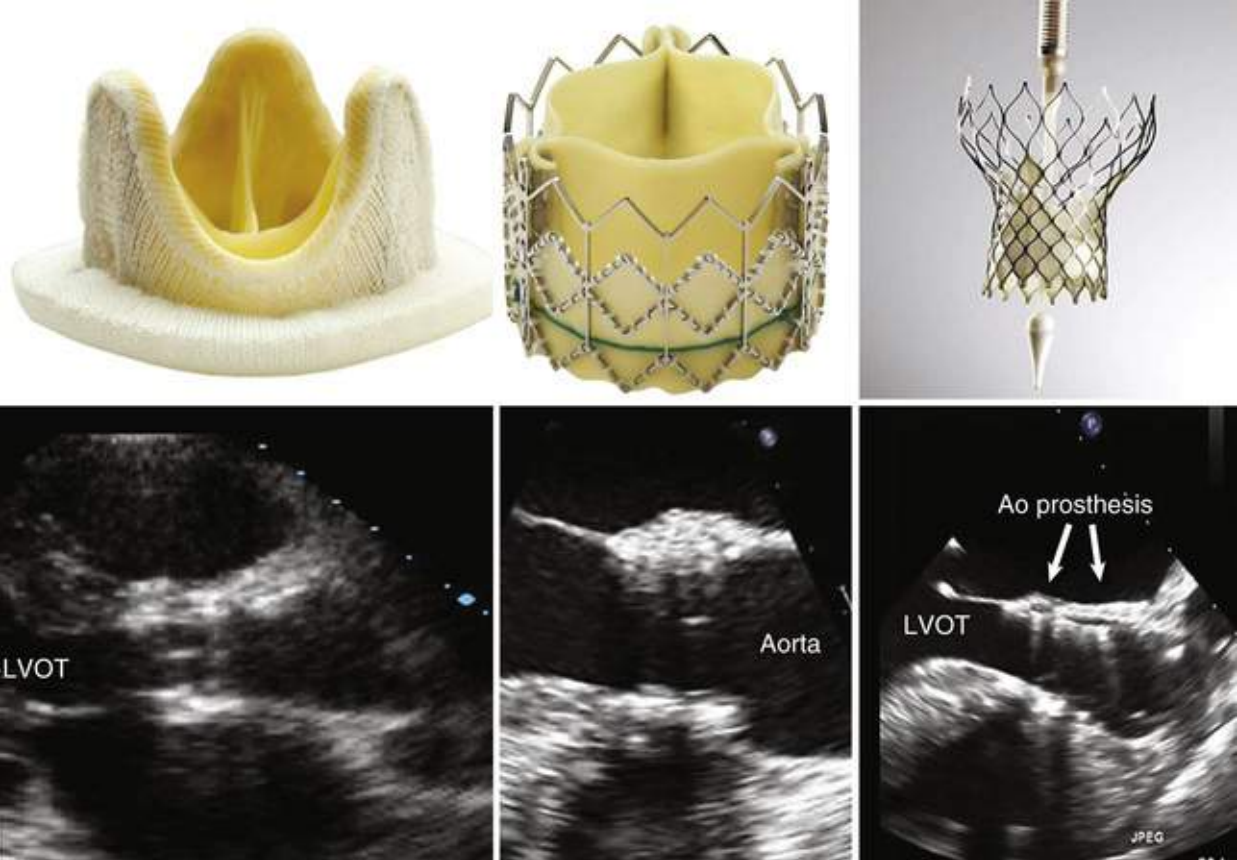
Bioprostheses and their echocardiographic long-axis appearance when implanted in the aortic (Ao) position. Left panels, Heterograft stented bioprosthesis. Middle panels, Sapien balloon expandable transcatheter aortic valve. Right panels, CoreValve self-expanding transcatheter aortic valve. *LVOT*, Left ventricular outflow tract.
